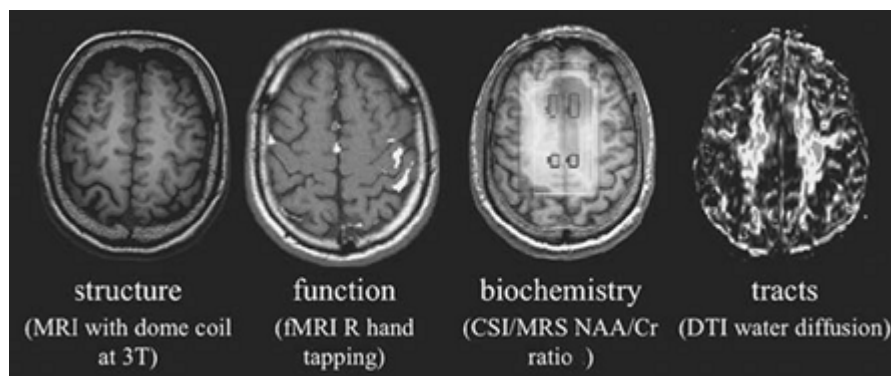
Advanced magnetic resonance imaging (MRI) in epilepsy. A range of advanced methods is
